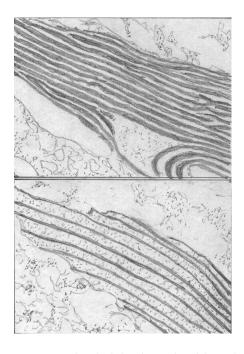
The thylakoids in the chloroplasts of Lingulodinium polyedrum display circadian differences. During the subjective night (CT 18) they lie closer together (upper part of the figure) as compared to the subjective day (CT6, lower part of the figure). Drawn by the author after a figure in Herman and Sweeney (1975)
